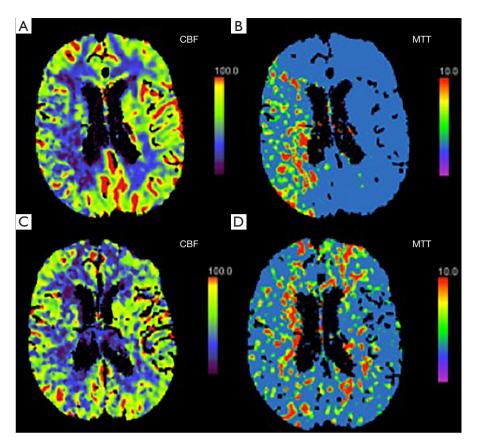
An 87-year-old male with near complete occlusion of his right internal carotid artery (not shown) with evidence of decreased cerebral blood flow (CBF) and increased mean transit time (MTT) throughout the right cerebral hemisphere on pre-operative CT Perfusion (A,B) indicating decreased perfusion. After carotid artery stenting, both the CBF and MTT are more symmetric with the contralateral hemisphere (C,D).
